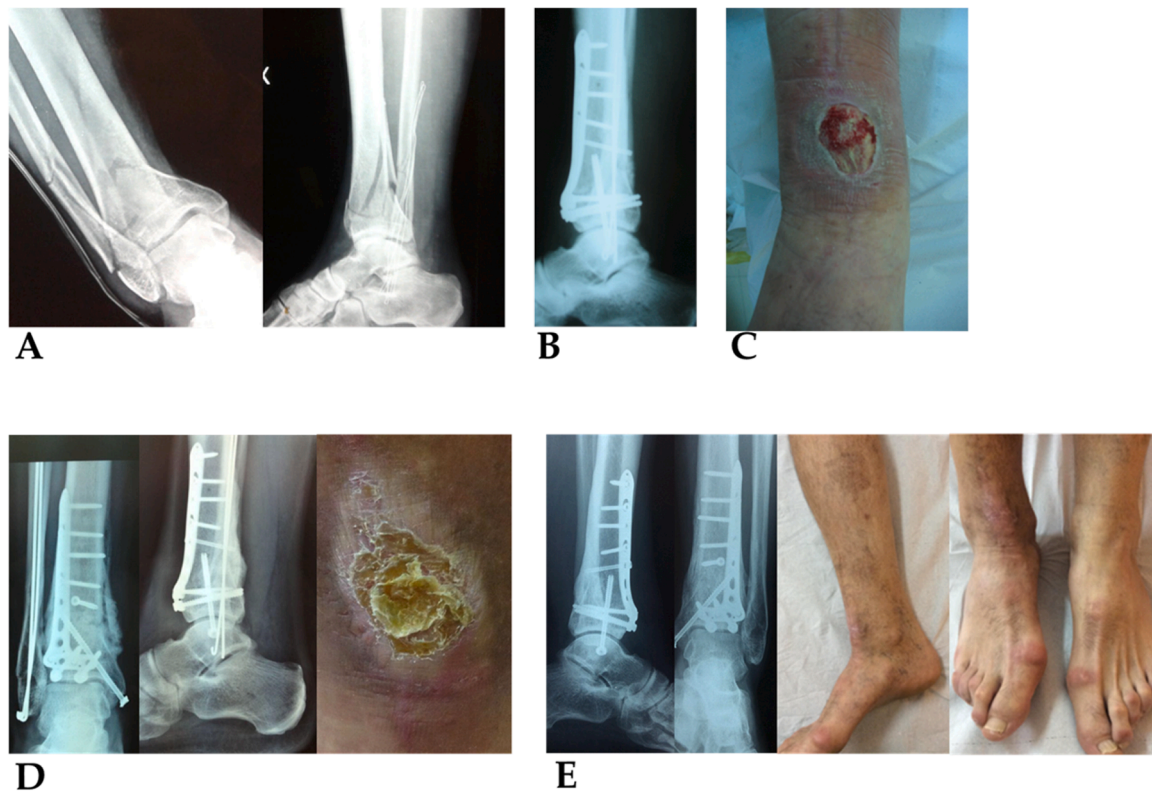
(A): Tibial pylon fracture. (B): After damage control with temporary EF and CT view following reduction and fixation with plates, screws, and definitive Kirschner wires (K). (C): At 4 months, soft tissue distress with *Pseudomonas aeruginosa* superinfection. (D): X-ray and clinical control at 2 months. (E): Clinical and X-ray control at approximately 8 months.
